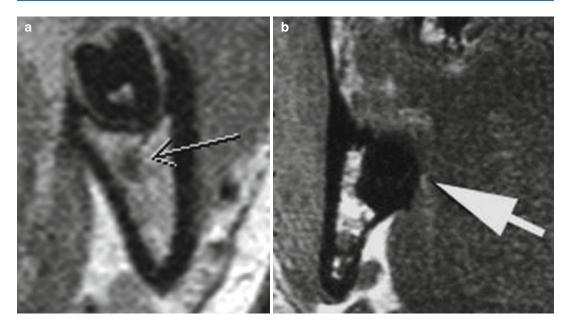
(a) High-resolution MRI (HR-MRI) image in the third molar region showing minimal detail of the inferior alveolar neurovascular bundle (*arrow*). (b)
